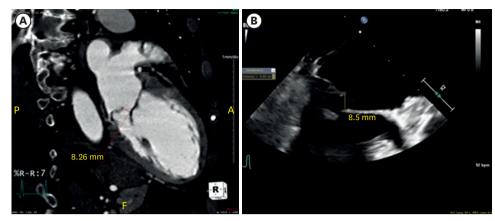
(A) shows flail gap measured on multi-detector computed tomographic angiography. (B) reveals measurements on 3-dimensional transesophageal echocardiography.
